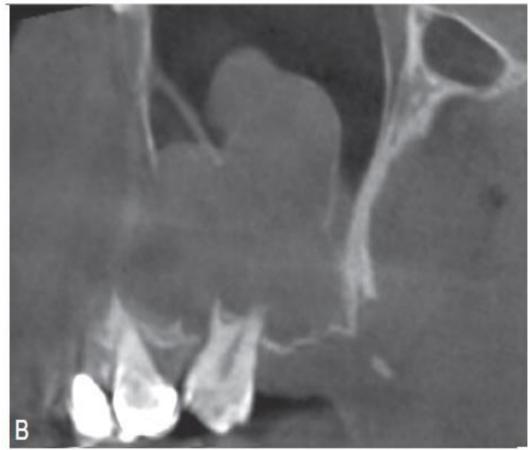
Ameloblastic Fibroma. A, Panoramic radiograph showing a destructive radiolucent lesion
